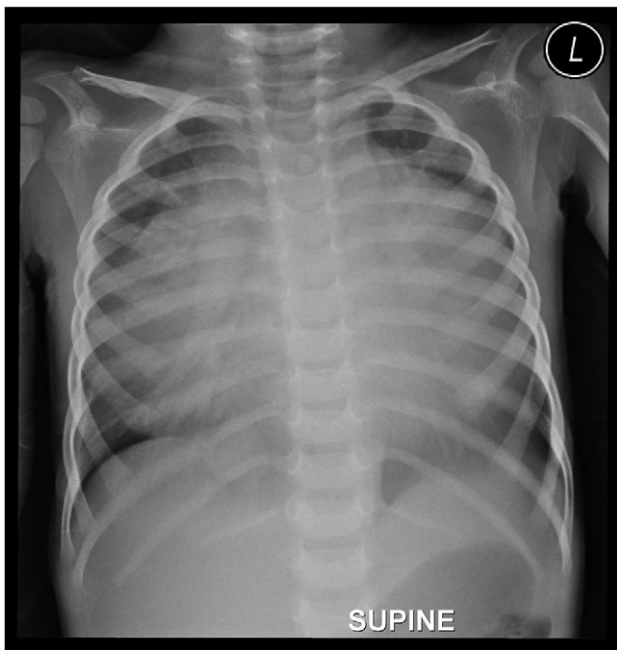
Preoperative chest roentgenogram showing cardiomegaly and massive pericardial effusion.
